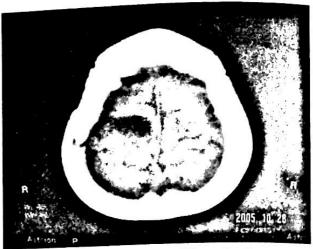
Post operative CT scan head.
